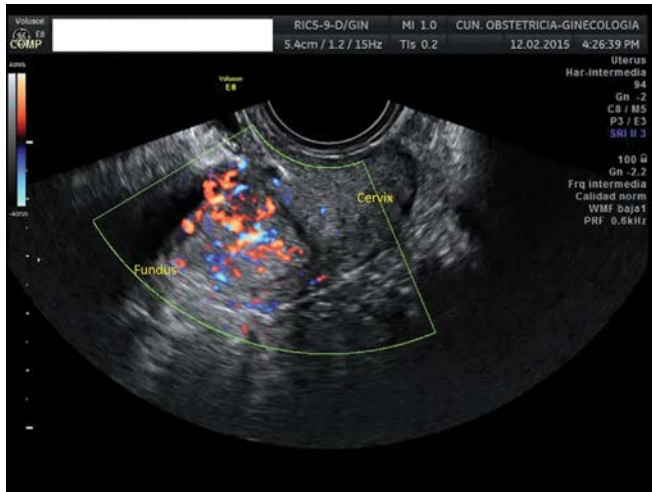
Transvaginal ultrasound showing a highly vascularized endometrium in a case of endometrial carcinoma.
